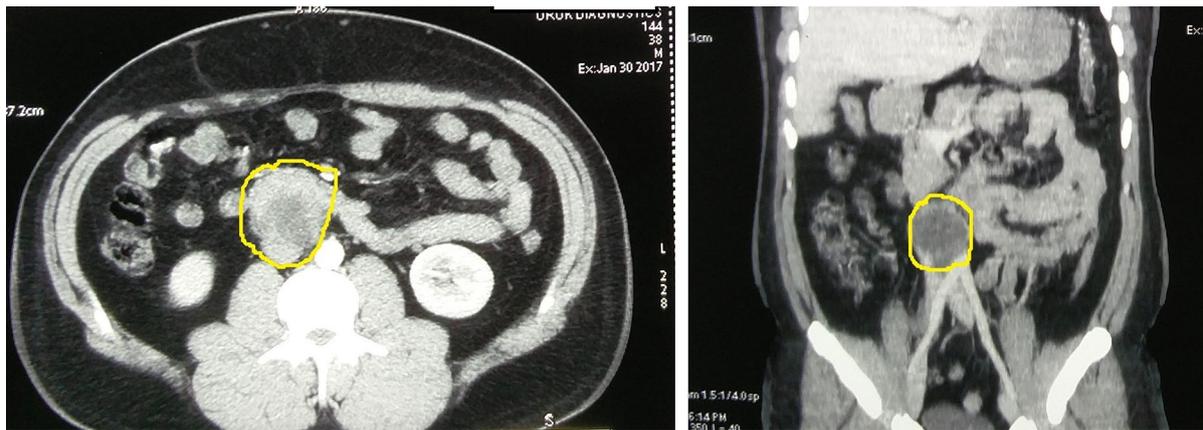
Computed tomography showing precaval and preaortic residual mass after chemotherapy
